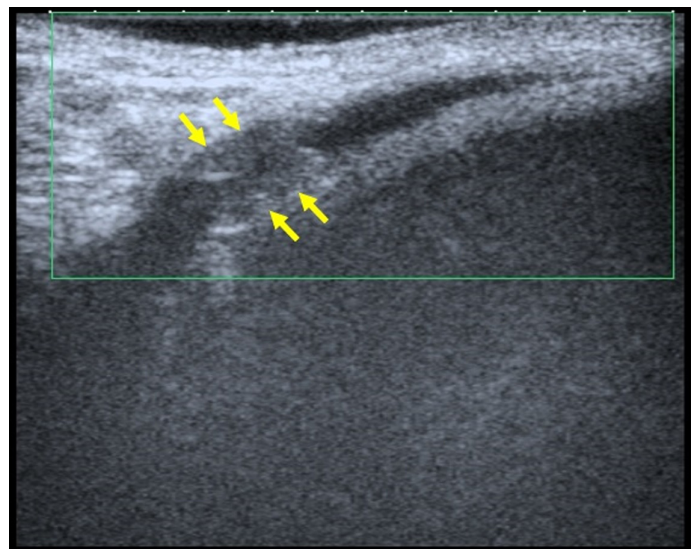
The thrombosis in the short segment of the superficial dorsal penile vein is clearly depicted in this color Doppler image (arrows).
